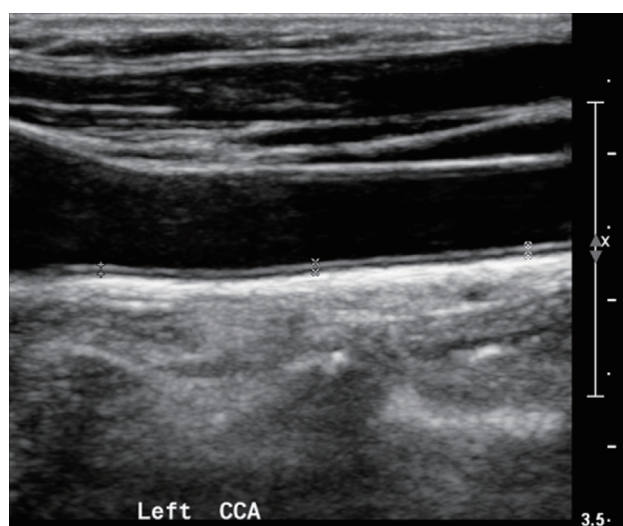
Normal carotid artery showing sites for measuring intima-media thickness. The arterial wall may demonstrate two parallel echogenic lines that are separated by a relatively hypoechoic intermediate area on longitudinal ultrasound, and the distance between these lines is the intima-media thickness.
